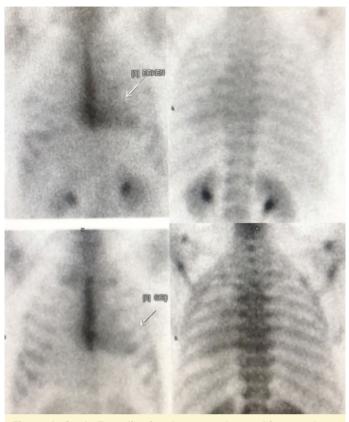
Grade 3 cardiac involvement observed in pyrophosphate scintigraphy.
